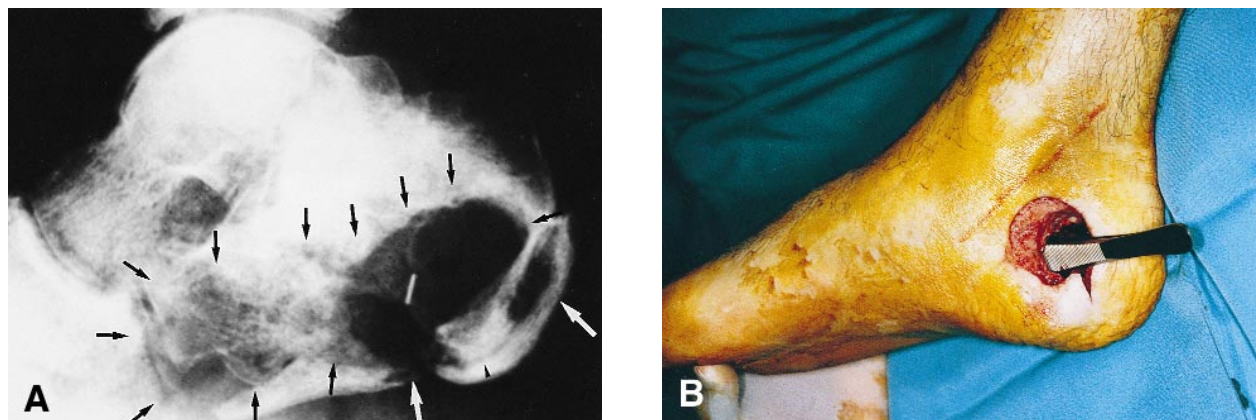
(A) X-ray after debridement. (B) Note the cavity left in the calcaneus.
